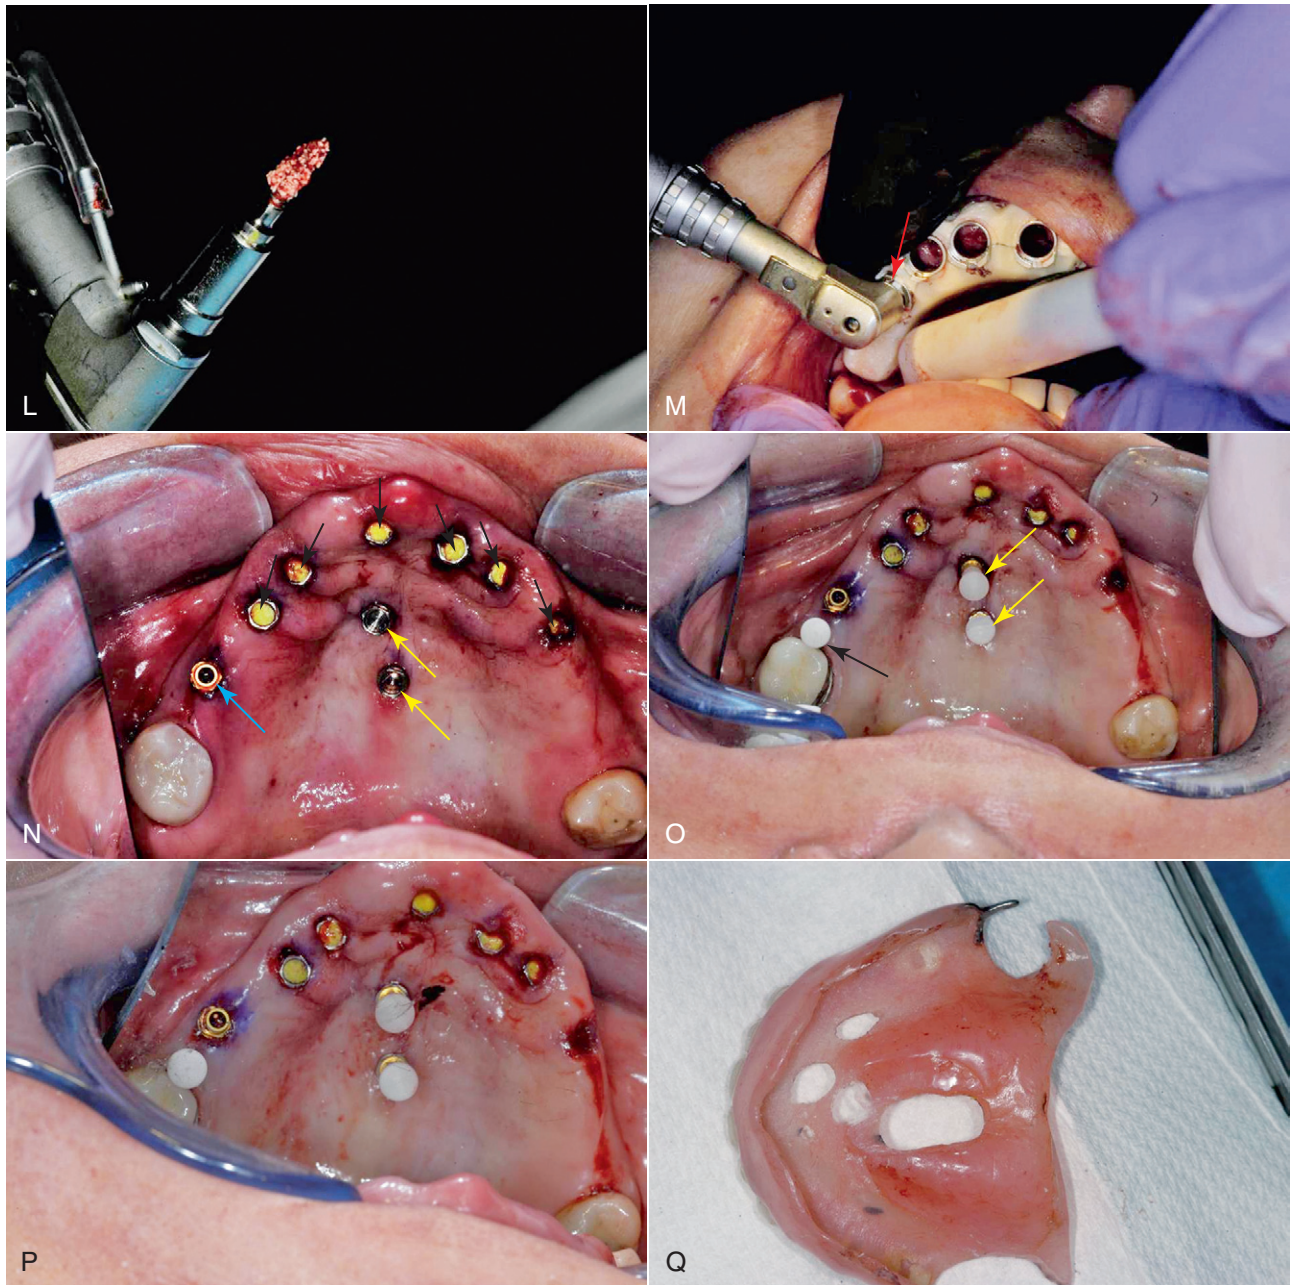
cont'd L, Insertion tool with 2.2- × 10-mm implant with graft material ready to be inserted back into the guide and placed into maxillae using a torque-limited surgical motor. M, A 2.2- × 10-mm ERA[®] mini implant (*arrow*) seated using insertion tool and surgical motor. N and O, Seven primary implants placed with the computed tomography (CT) guide. Two transitional implants are in the midline. N, *Black arrows*: six 2.2- × 10-mm ERA[®] mini implants after insertion shown with poly-vinyl material used to seal the female portion of the attachment during healing phase. *Blue arrow*: one 3.25- × 10-mm implant placed without guide. *Yellow arrows*: two 2.2- × 8-mm implants placed in the midline to be immediately loaded act as vertical stops to protect the primary implants during the healing phase. O, *Black arrow*: a previously prepared crown with an ERA[®] partial attachment and alignment sleeve. *Yellow arrows*: a 5° and 0° angle correction cemented and also an alignment sleeve. P, The path of insertion is parallel. The partial will be retrofitted. Q, Relieved partial denture with new clasps altered to achieve a passive fit before picking up the male ERA[®] black attachments in their metal housings. *Continued*
